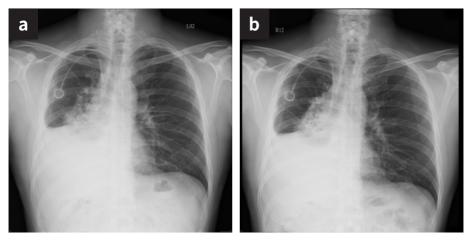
Chest radiograph indicating radiation pneumonitis. (a) First finding of right hilar infiltration and (b) increasing infiltration over the right hilum after antibiotic treatment.
